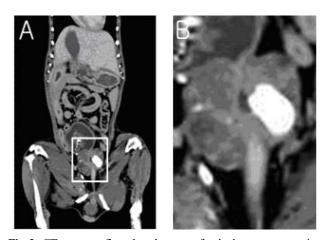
CT scan confirm that the part of calculus was protrusion within the prostatic urethra (A). (B) are the enlarged view of boxed area on (A).
